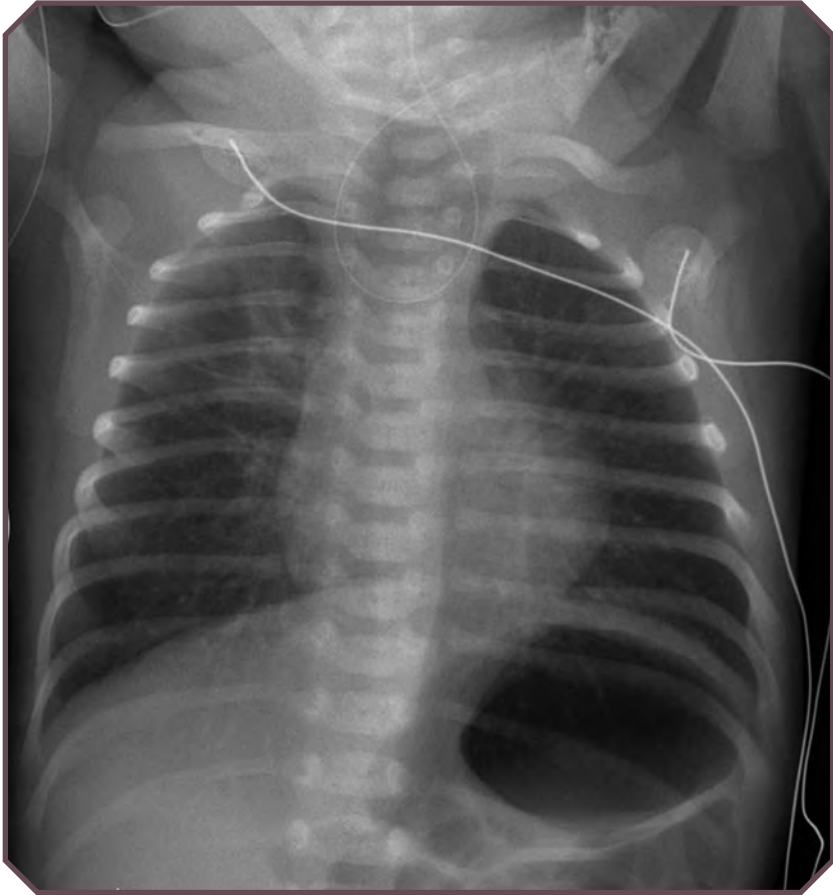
Esophageal atresia (type C) with distal fistula in a 2-day-old female neonate with difficulty feeding. Anteroposterior chest radiograph demonstrates a distended esophageal pouch containing a nasogastral tube that could not be passed. Air in the stomach indicates a distal tracheoesophageal fistula.
